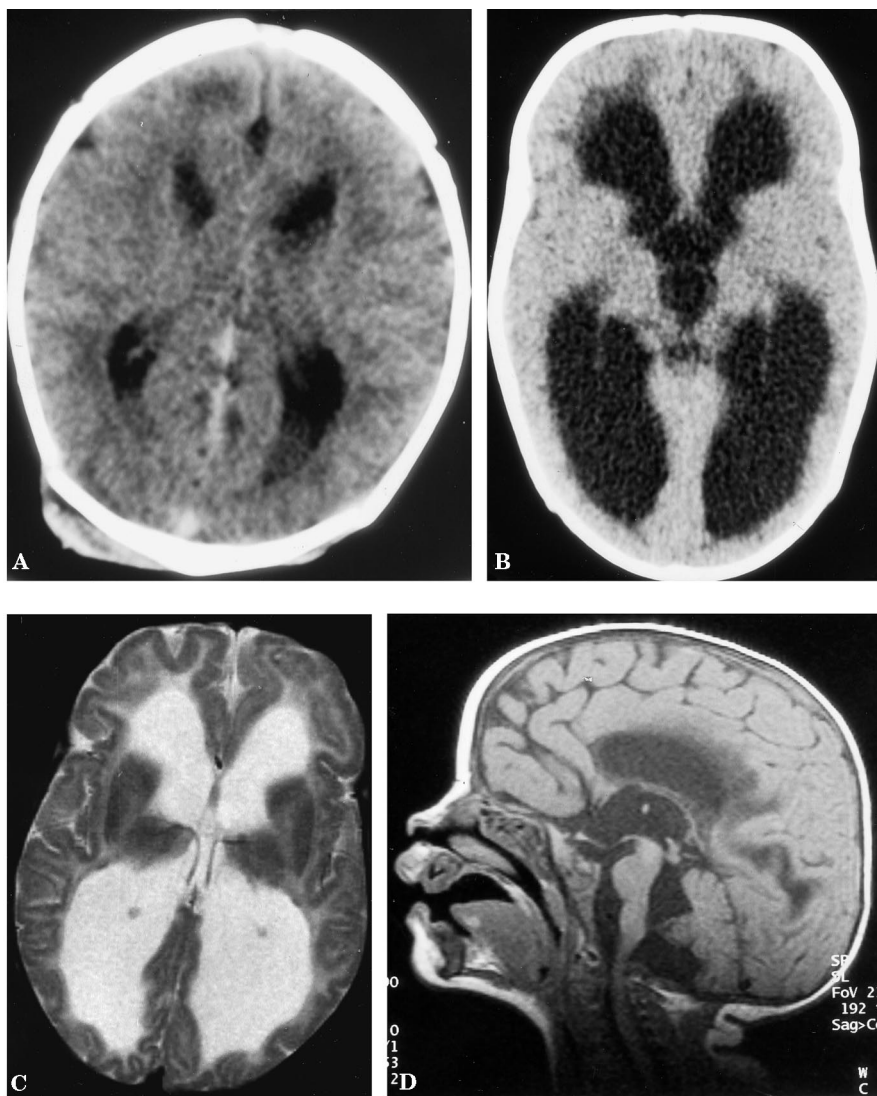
CT scan of Patient 1 taken in the first week of life (A), CT scan taken at age 4½ months at the time of the hydrocephalus (B), and MRI imaging after shunting at age 5 months in the axial (C) and sagittal plane (D).
